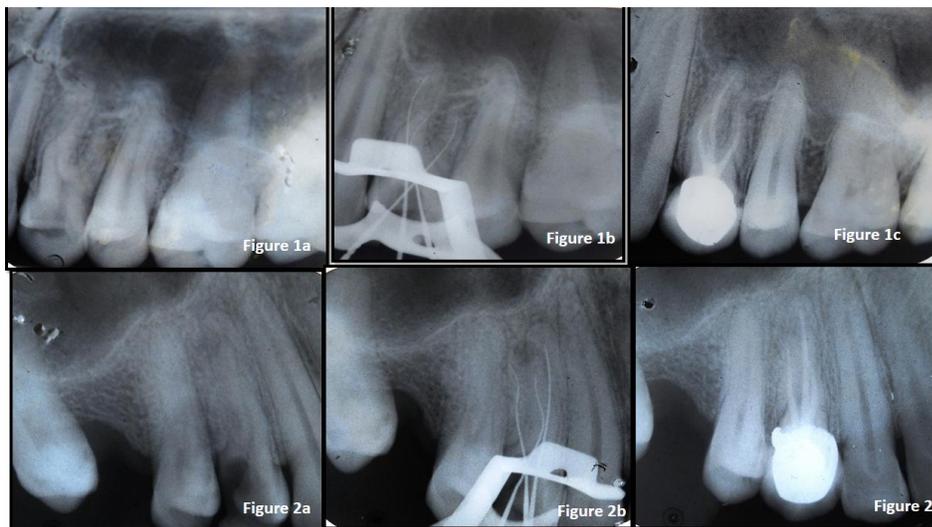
preoperative periapical radiograph; Figure 1b: working length radiograph; Figure 1c: post obturation radiograph; Figure 1d: follow up radiograph; Figure 2a: preoperative periapical radiograph; Figure 2b: working length radiograph; Figure 2c: post obturation radiograph.
